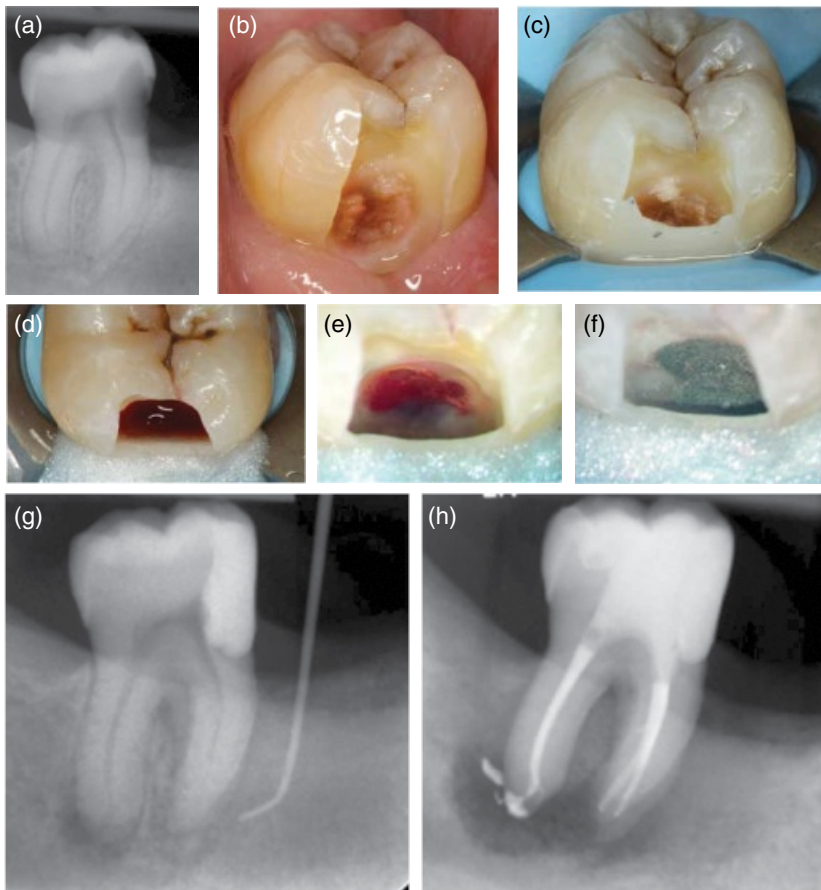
Clinical example of a Class II direct pulp-capping procedure (male, 48 years). (a) Preoperative radiograph reveals a deep lesion and no apical pathosis. (b) Carious tissue removal shows that the lesion is located deep down at the approximal site. (c) A small build-up filling is placed at the margin to facilitate asepsis. (d) A bleeding exposure is noted. (e) Hemostasis is about to be reached. (f) Application of calcium silicate cement. (g) After 3 months, the patient presents with a sinus tract and apical periodontitis. (h) An immediate postoperative radiograph of completed root canal treatment. Case courtesy of Dr Pim Buurman.
